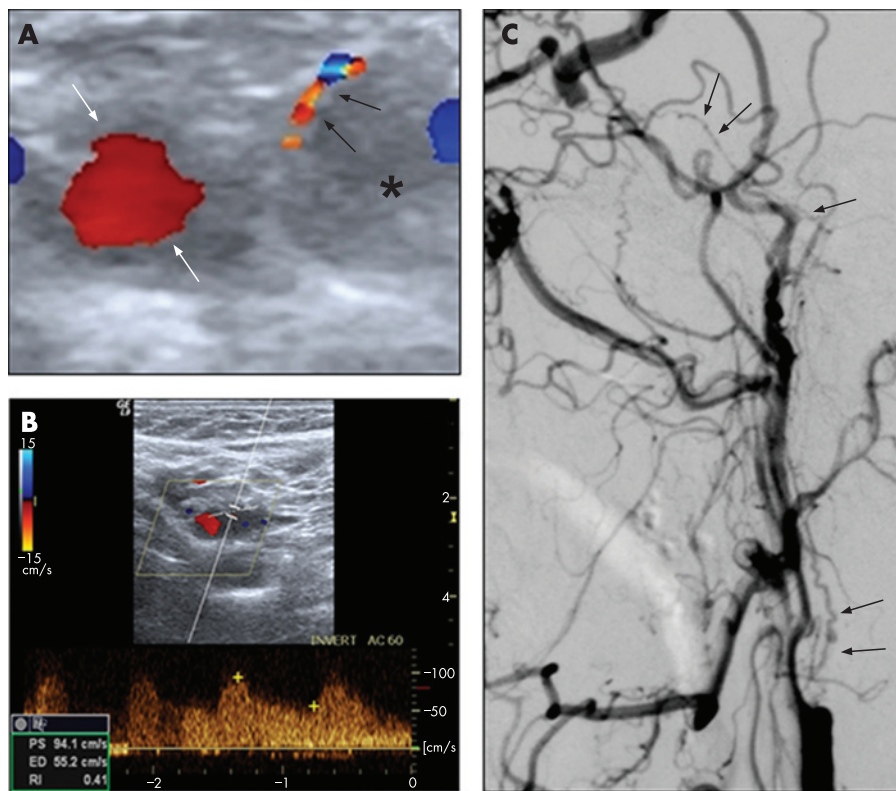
(A) Colour coded duplex ultrasonography, transverse section, 1 cm above the carotid bifurcation, shows the occluded internal carotid artery (ICA) lumen (*) and a thin segment of flow within its wall (black arrows), outlining the perimeter of the artery. External carotid artery is normal (white arrows). (B) Spectral tracing from the same segment as in (A), reveals a normal waveform and velocity. (C) Contrast arteriogram of the left ICA, arterial phase, lateral view, demonstrates a rounded proximal stump. Spiral vasa vasorum (black arrows) originate from the bulb and contribute to the filling of the cavernous segment. The true lumen of the ICA is never filled.
